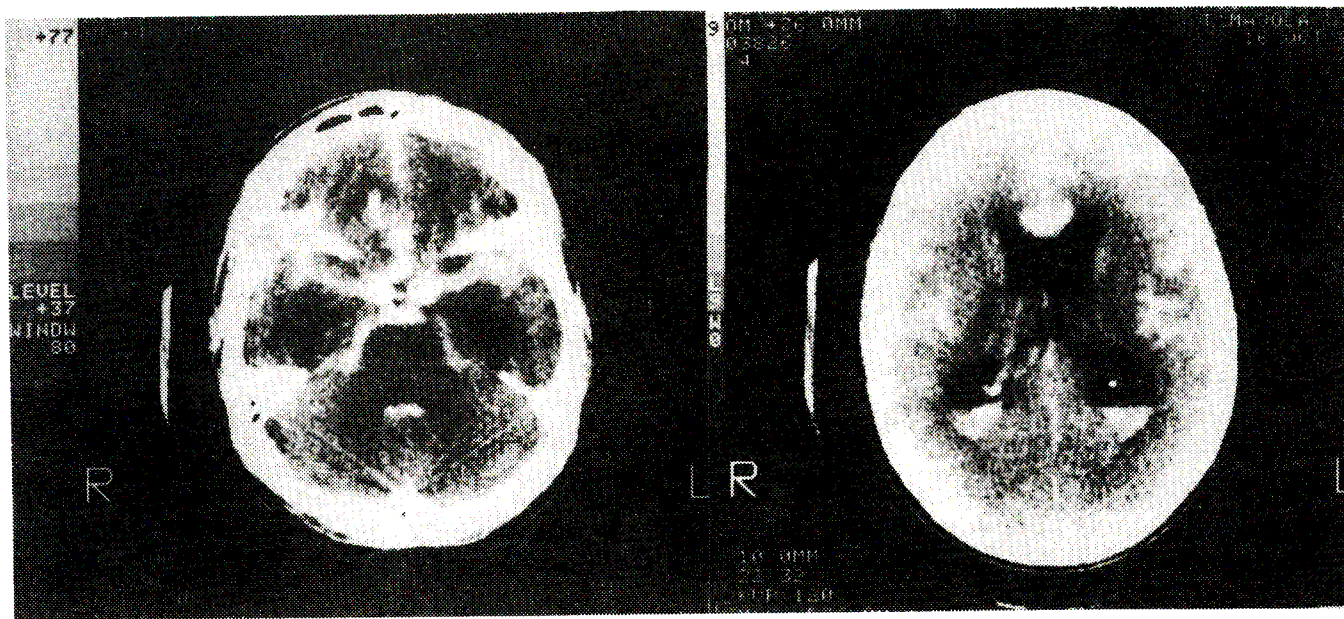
(a,b). CT on admission (CT-Fisher grade 3)
